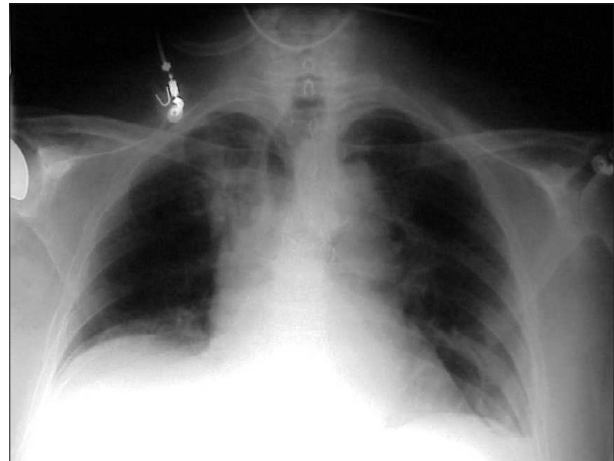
Immediate postoperative chest X-ray showing elevated right hemidiaphragm.
